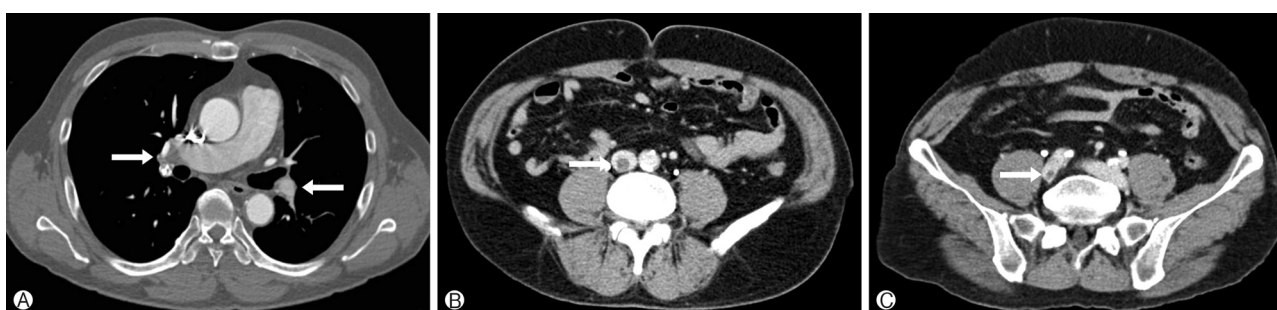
After 3 months of anti-coagulation treatment, follow-up computed tomography scans showed the decrease size of thrombus both in pulmonary artery (A) and infrarenal inferior vena cava (B) to the right common iliac vein (C) (Fig. 2).
